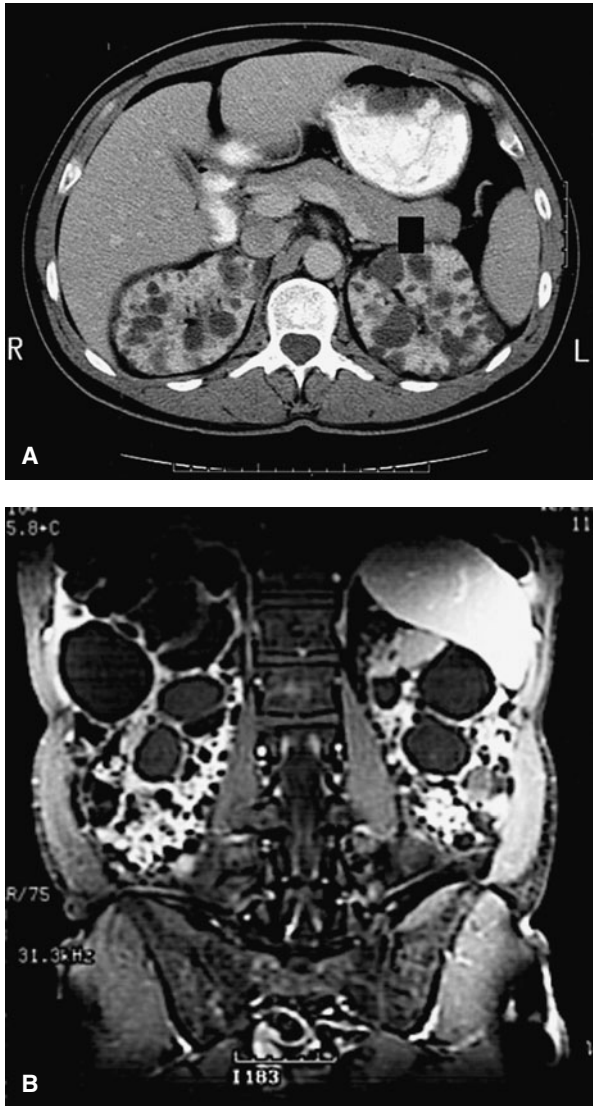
Adult polycystic kidney disease. A. CT scan of the kidneys demonstrates bilateral renal cysts in a patient with ADPKD. B. Magnetic resonance imaging (MRI) of the kidneys also notes large cysts, which can cause pain from capsule distension, rupture, hemorrhage, or infection. (Courtesy of Mark A. Perazella.)
